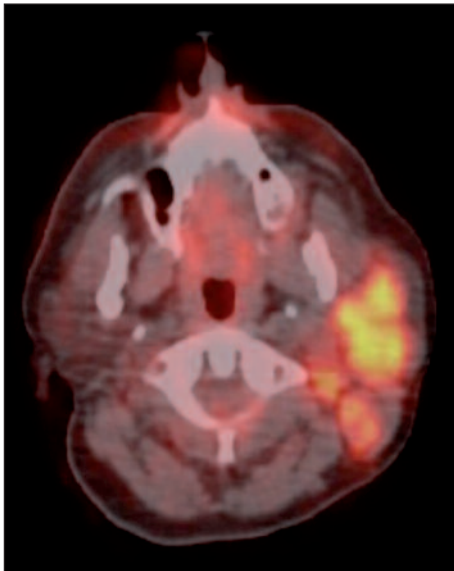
PET-CT scan of the patient that shows increased 18F-FDG uptake on the left pre-auricular, infra-auricular, parotid localization.
